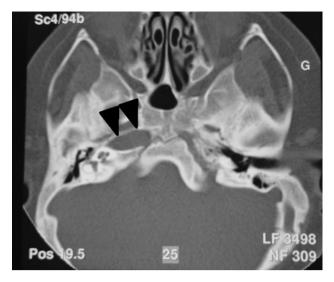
High-resolution CT scan of the skull base. The left carotid canal is completely absent. The right carotid canal can be clearly seen (*arrowhead*)
